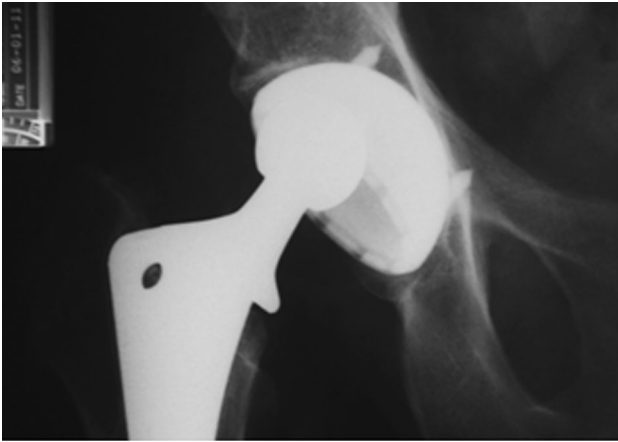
Diagnostic radiographs revealed migration of the femoral head within the cup.
